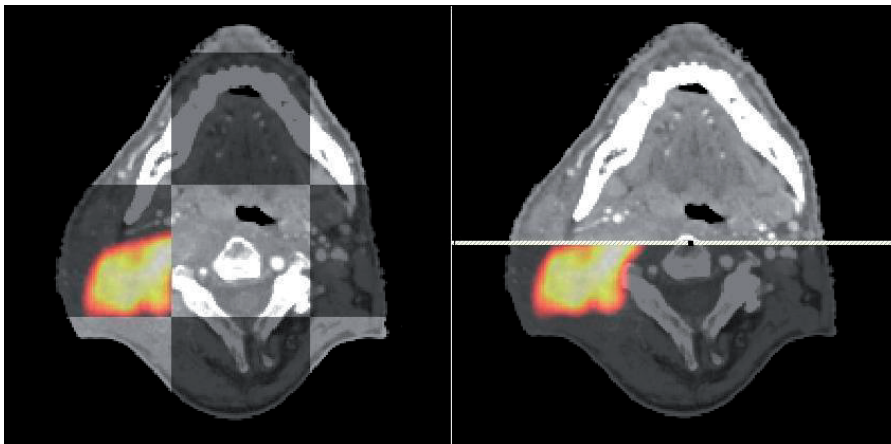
CT image with colour PET overlay. Two types of split views are shown.
